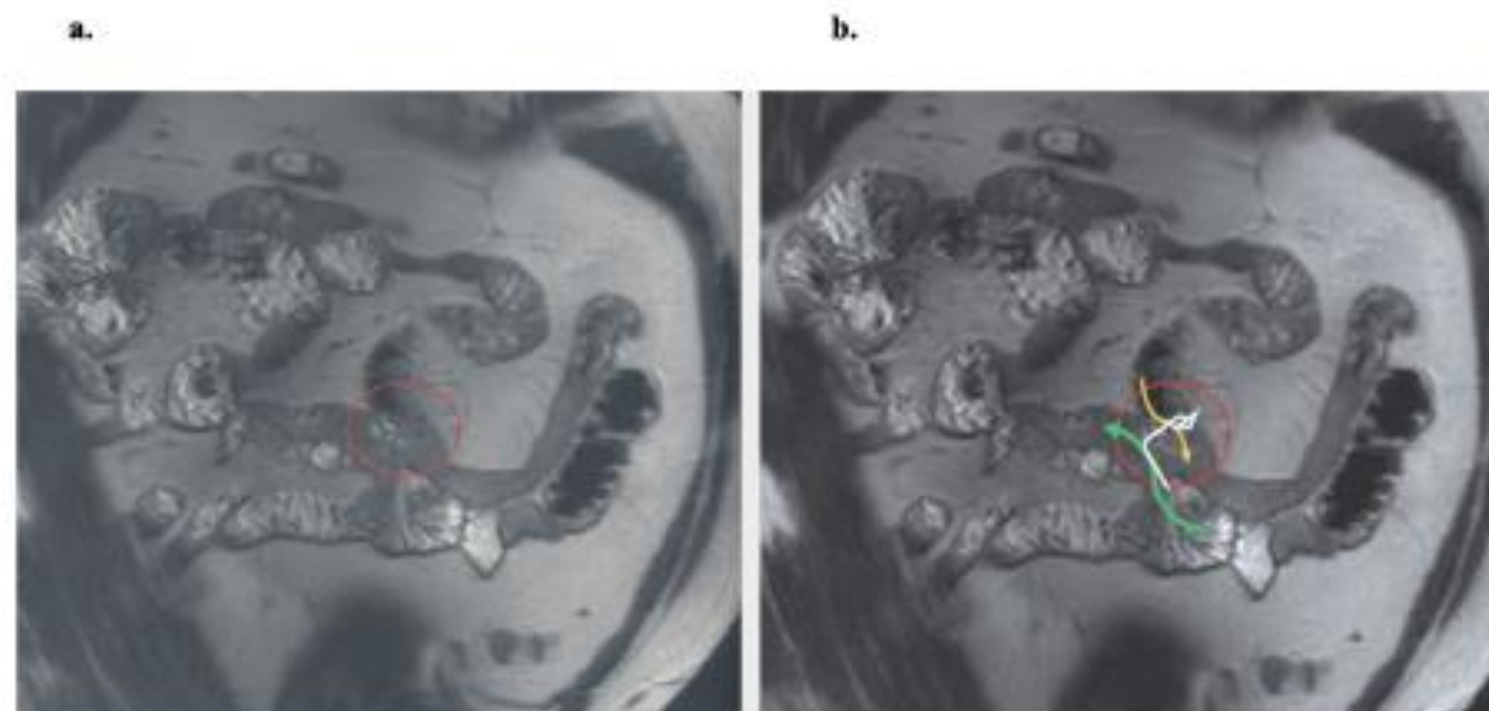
a, b At 90 and 180 days post procedure, MRI enterography visualized patent jejunum-ileal anastomosis site in all patients
